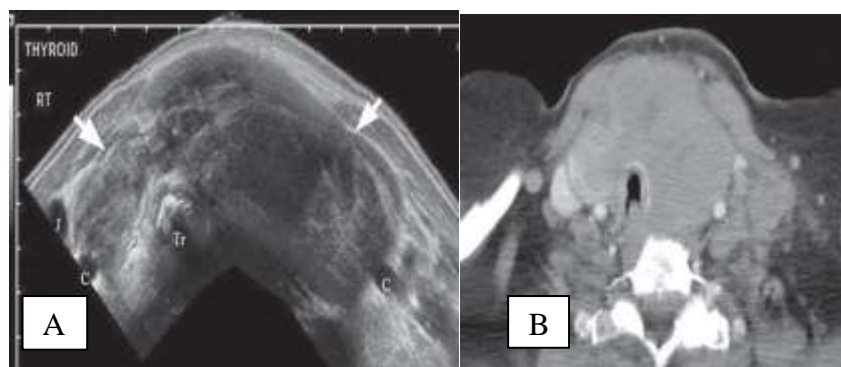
Anaplastic thyroid carcinoma . *A, Transverse image shows large hypoechoic mass (arrows) involving the entire gland, greater on the left, which causes deviation of the trachea to the right; Tr, tracheal air shadow; C, common carotid artery; J, jugular vein. B, Contrast-enhanced CT scan of the patient shows the large mass and its relationship to adjacent structures.*
